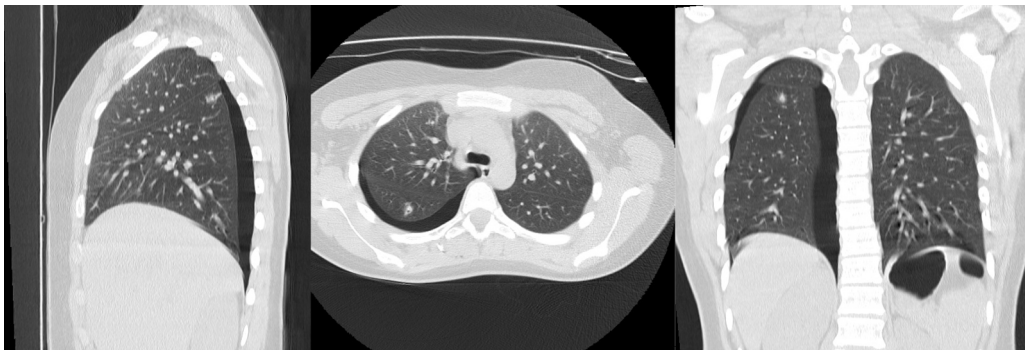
Thoracic CT scan: right-sided pneumothorax with laceration of the right lower lobe of the lung.
